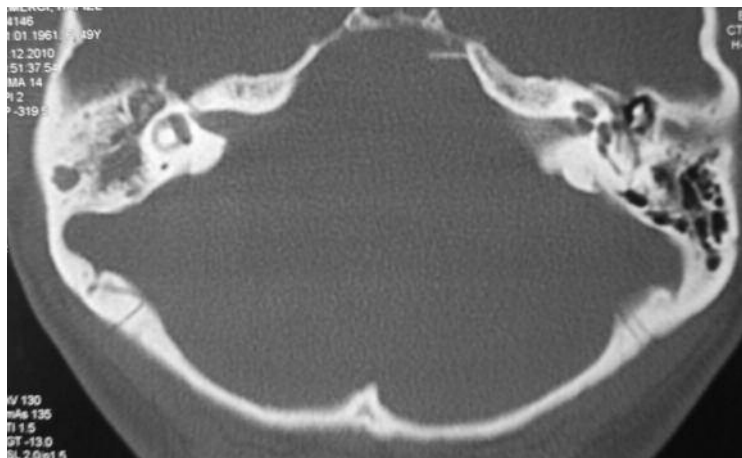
Axial CT scan of the temporal bone shows thickening of the mucosa of the middle ear and mastoid cavity on right side.
